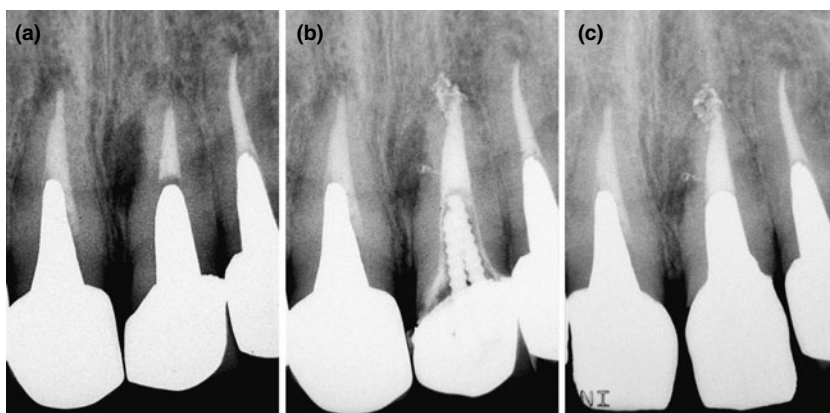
Case 1: (a) Preoperative radiograph of maxillary central incisor showing lateral and apical radiolucencies. (b) Radiograph taken immediately after treatment showing obturation of lateral canal and apical branches which caused endodontic lesions. (c) Follow-up radiograph 2 months after treatment showing significant bone healing.
